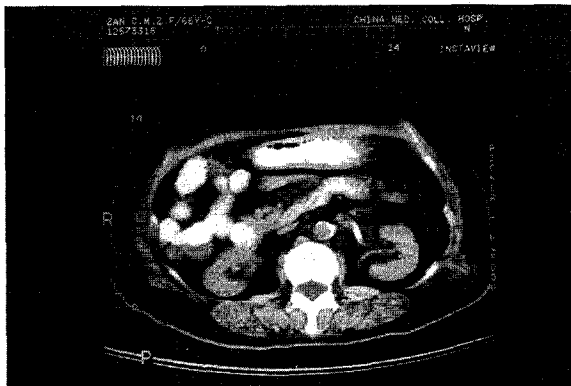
Abdominal computed tomography showing complete resolution of the cystic cavity.
